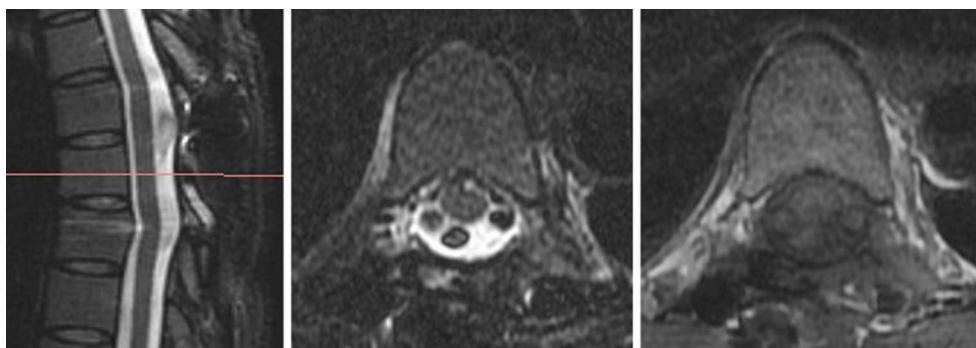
Postoperative magnetic resonance imaging (MRI) obtained 2 years after the surgery. At the 2-year post-surgery follow-up, MRI revealed no evidence of local recurrence
